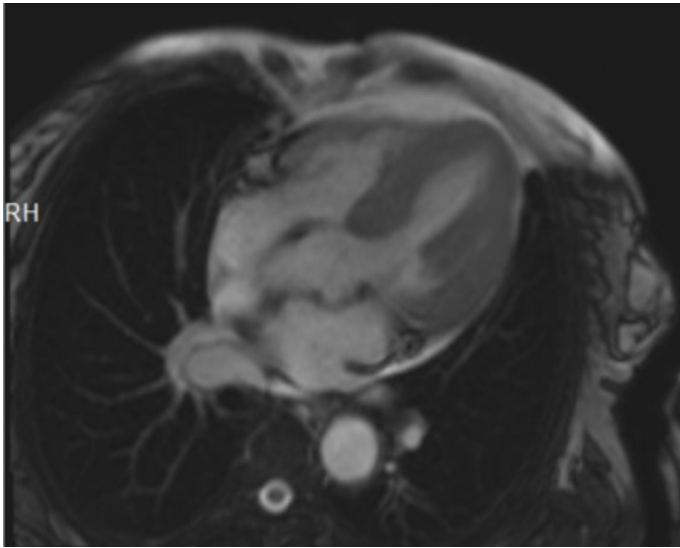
Cardiac magnetic resonance imaging findings.
